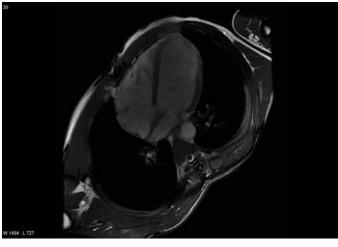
On cardiac magnetic resonance imaging (4-chamber view), note myocardial fibrosis of the left ventricle lateral wall on late gadolinium enhancement (arrow). The fibrosis affected 15% of the left ventricle surface and up to 50% of left ventricle lateral wall thickness and therefore was associated with a dyskinetic segment in systole.
